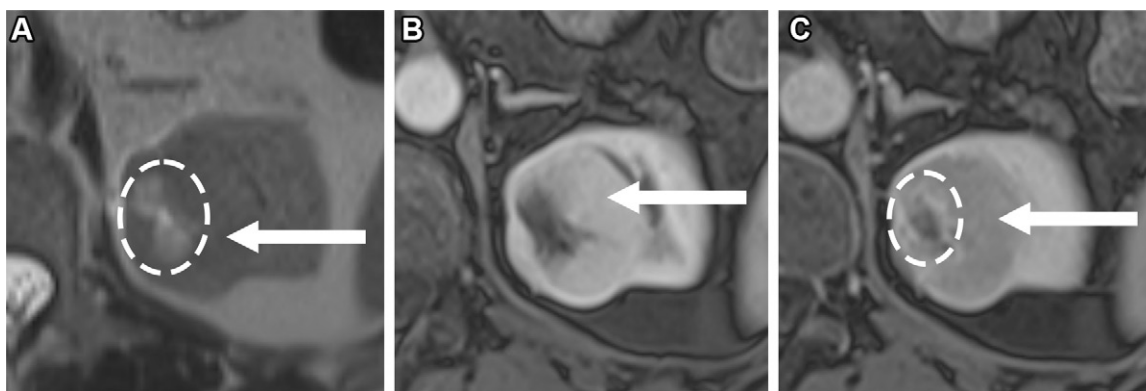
Oncocytoma in a 56-year-old woman with smoldering multiple myeloma incidentally detected at fluorodeoxyglucose PET/CT. (A) Axial T2-weighted MR image shows a predominantly T2-isointense 4.4-cm left renal mass (arrow), which is a central T2-hyperintense scar (dashed oval). (B) Axial postcontrast delayed phase CMP T1-weighted MR image shows intense enhancement of the periphery of the mass (arrow). (C) Axial postcontrast T1-weighted MR image shows SEI, in which the hypoenhancing central portion of the mass is heterogeneously hyperenhancing (dashed oval) relative to the peripheral component (arrow), which was hyperenhancing during the CMP in B. The ccLS is 3 (intermediate likelihood of ccRCC), with a differential diagnosis of oncocytoma based on the presence of SEI. Oncocytoma was diagnosed at left partial nephrectomy.
